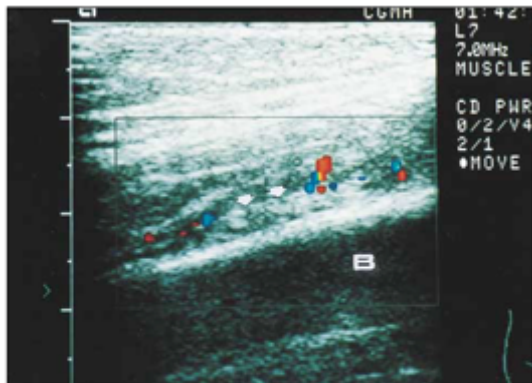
Initial CDUS image (case 6) demonstrates color Doppler vascular flow within and around the periosteum (arrows). Patients with this CDUS feature usually have symptoms for more than 4 days. B, Bone.
